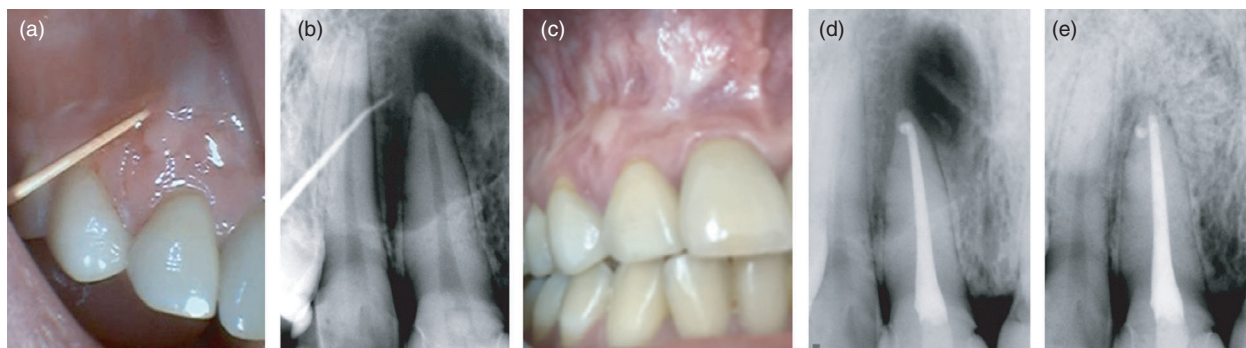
Representative case of a tooth with associated sinus tract categorised as healed. (a and b) Tracing the sinus tract with a gutta-percha point. (c) Postobturation radiograph. (d) Follow-up radiograph showing periradicular bone healing after 2 years.
